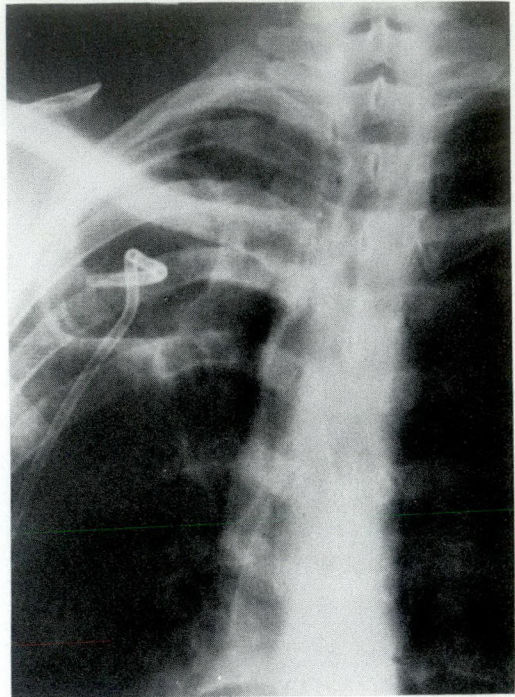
J.B. Chest radiograph October 22, 1941. Monaldi drainage. An indwelling catheter drains a large cavity at the right apex. This cavity later closed.
